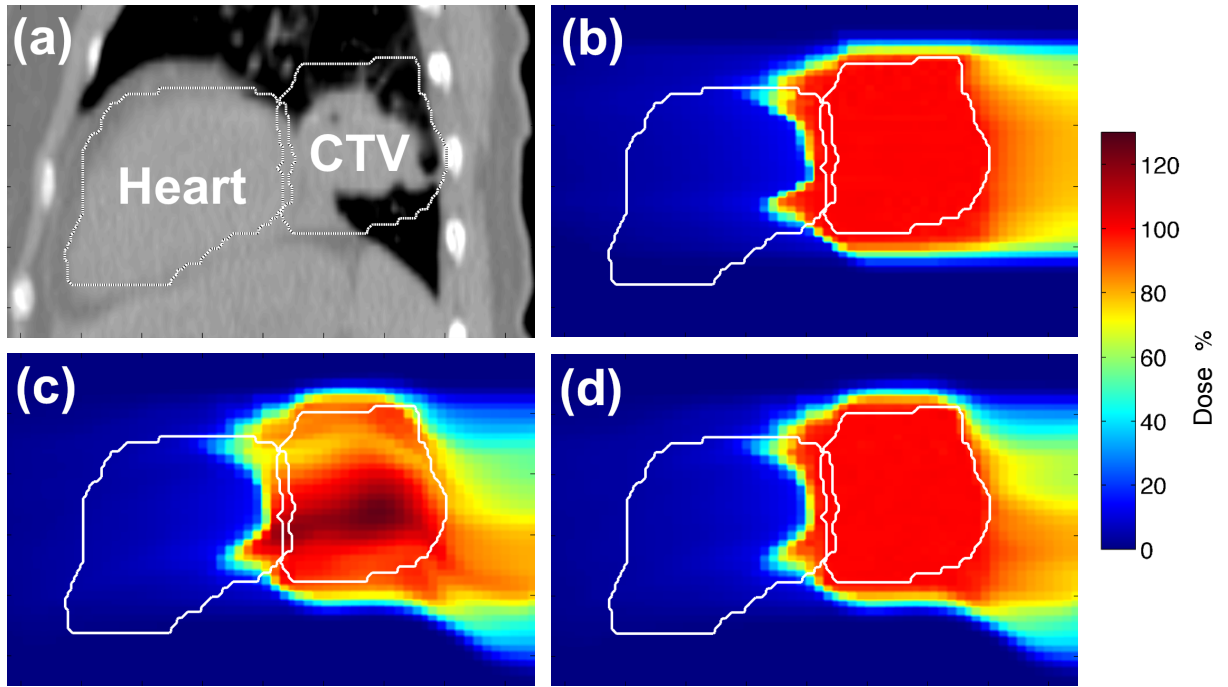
Sagittal cuts showing (a) CT image of lower thorax, (b) 3D dose for the 3D-optimized carbon static plan ignoring motion, (c) 4D dose for the 3D-optimized beam tracking plan, (d) 4D dose for the 4D-optimized carbon beam tracking plan. All 4D dose distributions were transformed to the reference motion state at end-exhale for analysis. Note the increased uniformity of CTV dose using 4D-optimized beam tracking (d) instead of 3D-optimized beam tracking (c).
